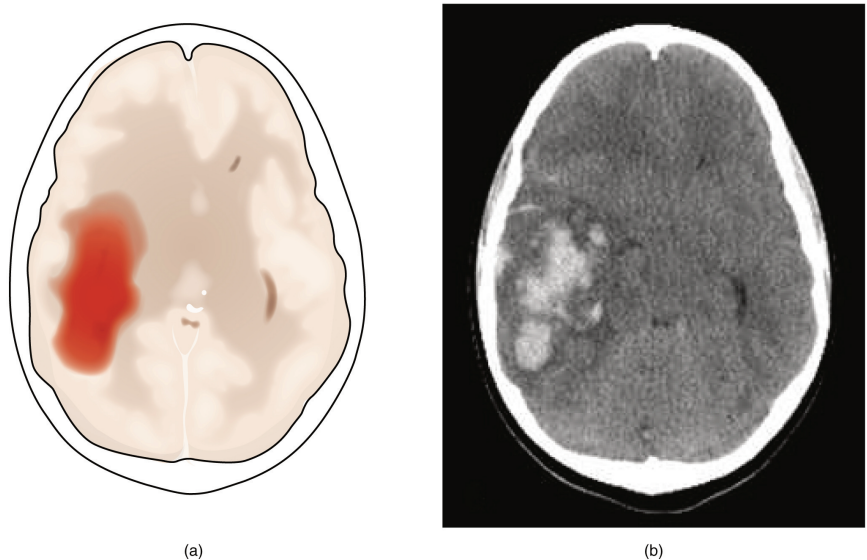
(a) A hemorrhage into the tissue of the cerebrum results in a large accumulation of blood with an additional edema in the adjacent tissue. The hemorrhagic area causes the entire brain to be disfigured as suggested here by the lateral ventricles being squeezed into the opposite hemisphere. (b) A CT scan shows an intraparenchymal hemorrhage within the parietal lobe. (credit b: James Heilman)
